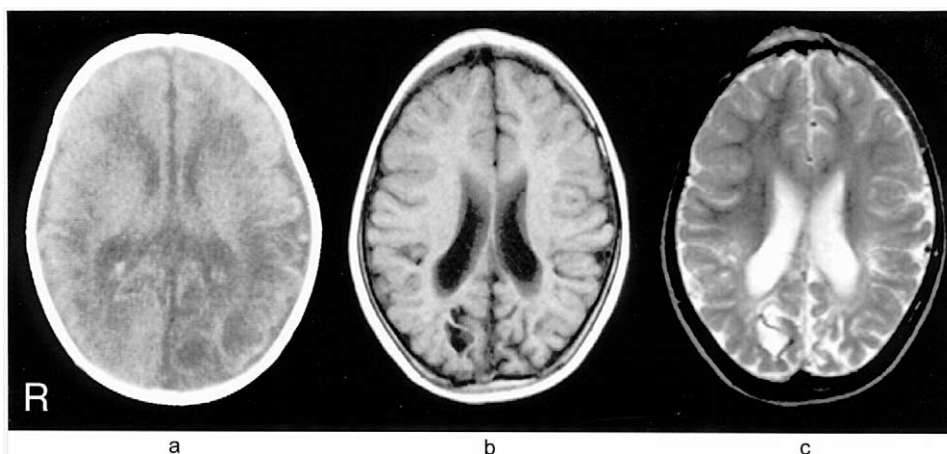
CT and MRI findings in case 1. (a) CT at 40 weeks of conceptional age. Abnormal low density areas in the bilateral parieto-occipital regions were recognized. (b) A T1-weighted image (TR 450 ms, TE 14 ms) and (c) a T2-weighted image (TR 2000 ms, TE 120 ms) on MRI at 5 years of age demonstrated atrophy in the bilateral parieto-occipital regions.
